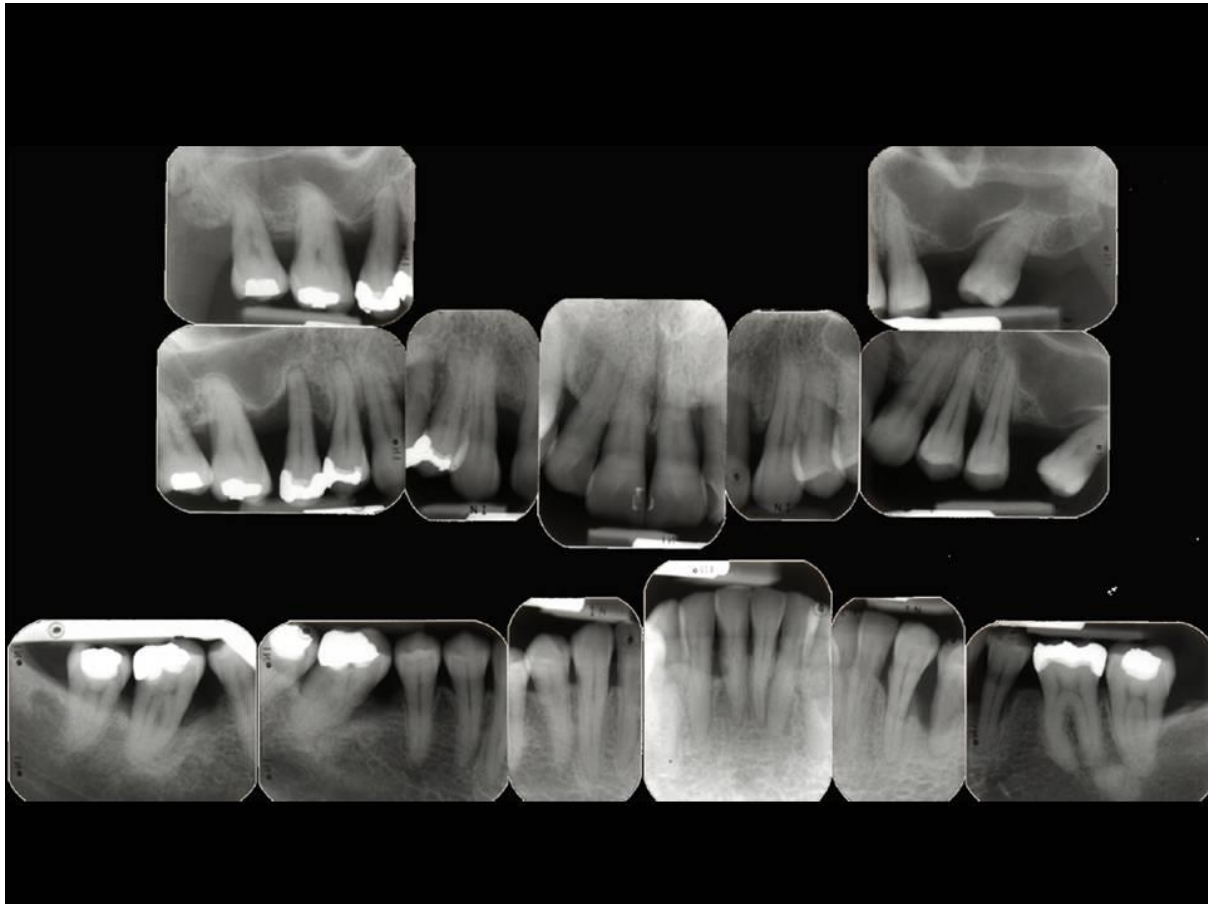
Periapical radiographs
